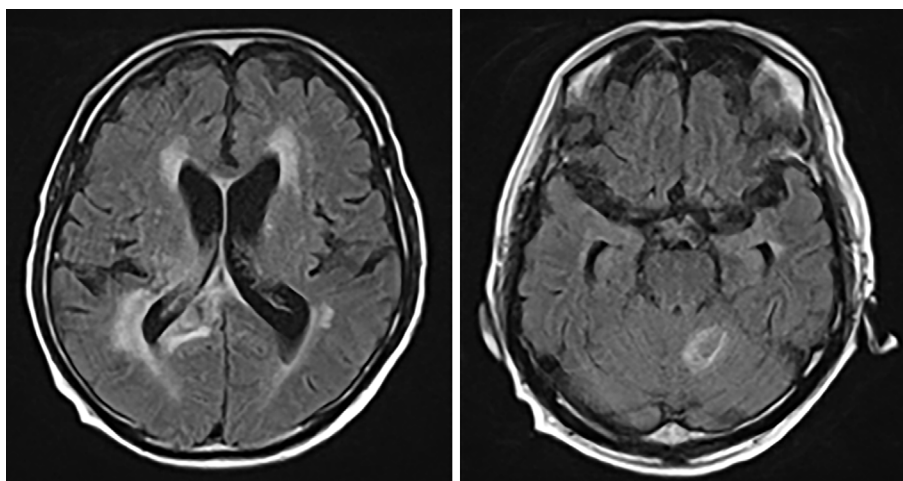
Brain MRI using FLAIR on admission.
